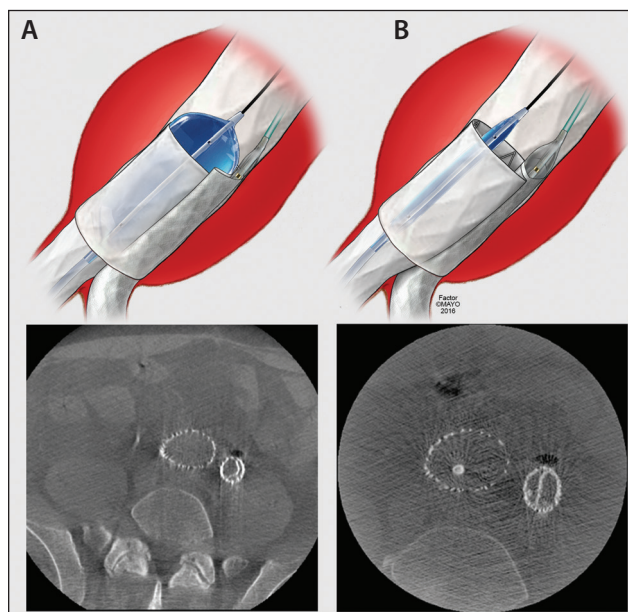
Intraoperative cone-beam CT was used in this patient who was treated with an aortic stent graft and parallel iliac stent grafts. Note compression of the internal iliac bridging stent (A). This was immediately revised by placement of balloon-expandable stents to achieve perfect "D" configuration (B). Used with permission of Mayo Foundation for Medical Education and Research. All rights reserved.
